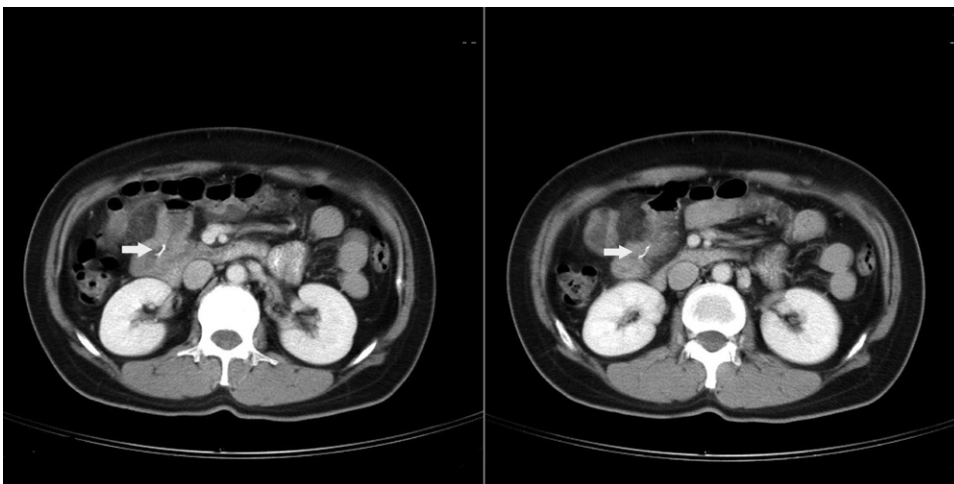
On plain radiography, the arrow points to a fishhook-shaped foreign body.
